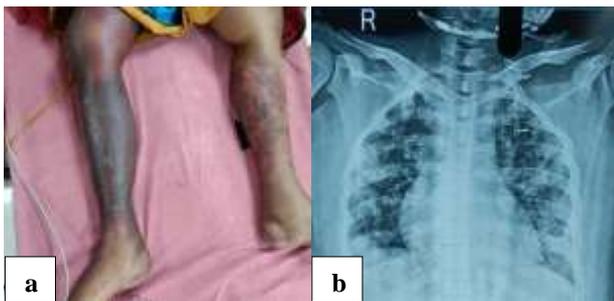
(a) Lower limb skin discoloration – due to metastatic septic emboli, and (b) chest X-ray with diffuse peripheral nodules and cavitation.
